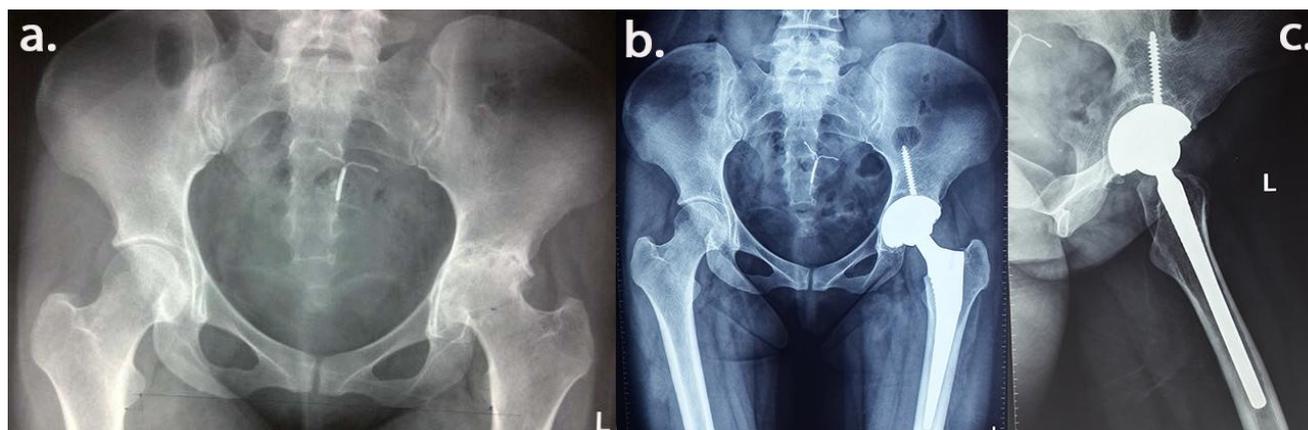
CoC THR in young adult patient with rheumatoid arthritis. A) pelvic radiograph before surgery; B and C) post- CoC THR radiography
